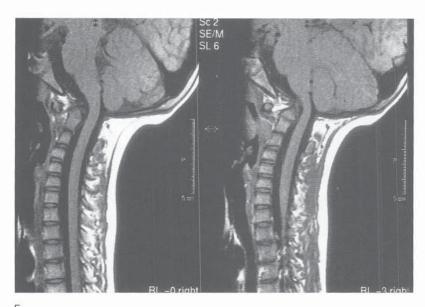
Continued. E, Anterior impingement of the lower brain stem due to basilar impression. F, Radiographic appearance 4 months after a posterior occiput-C3 fusion to prevent neurologic deficit.
